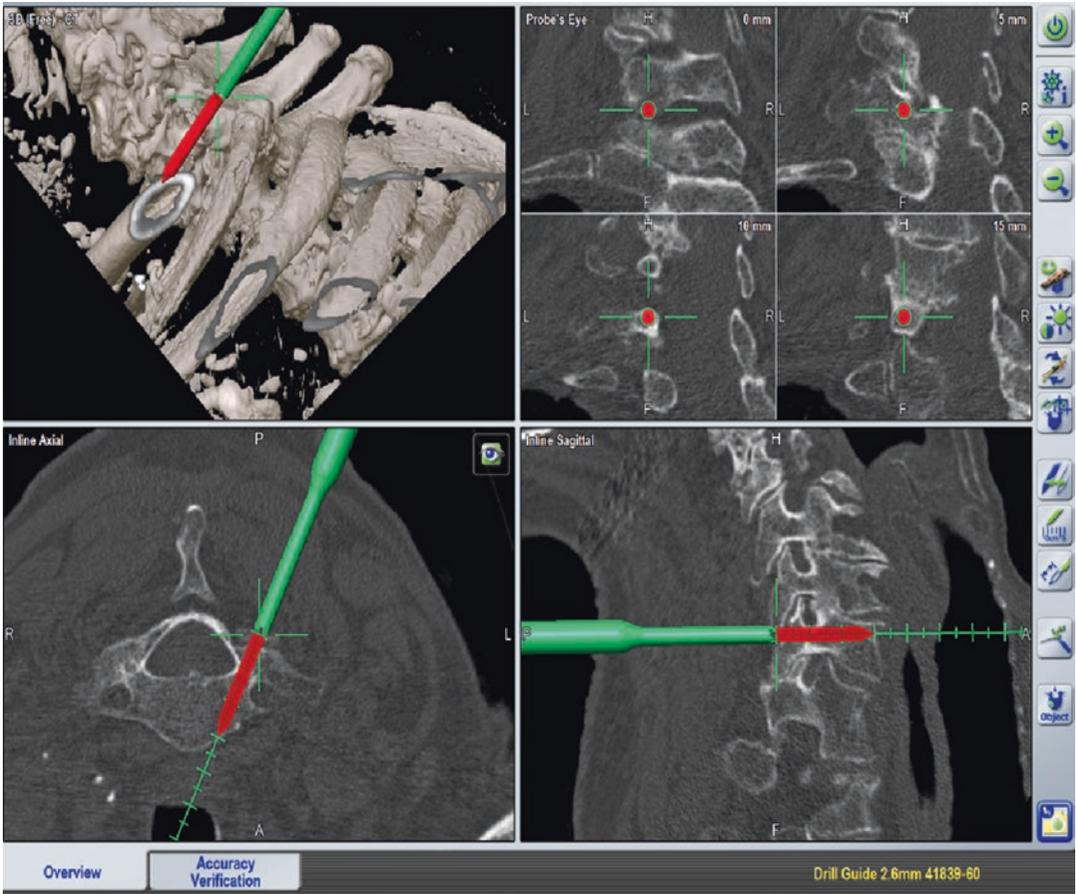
Intraoperative CT-region matching based pedicle screw trajectory of the cervical spine
